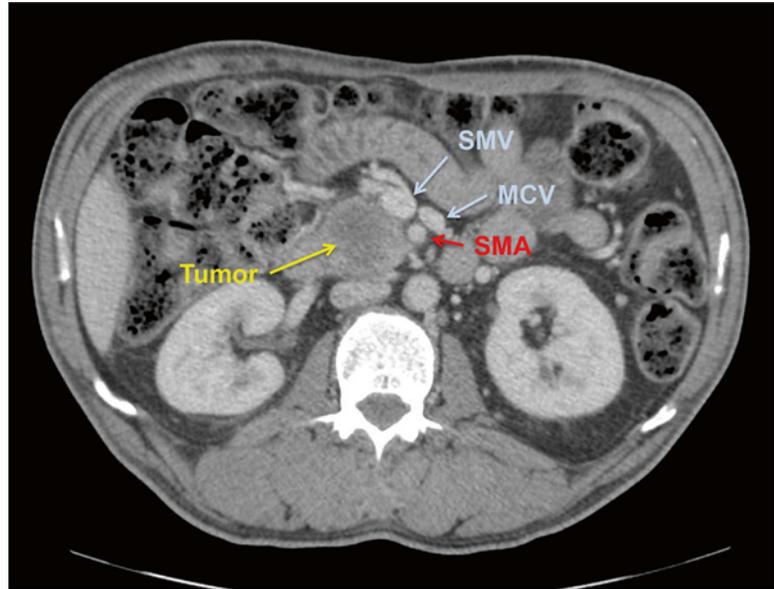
CT scan demonstrating a borderline resectable pancreatic adenocarcinoma with tumor thrombus within the SMV
